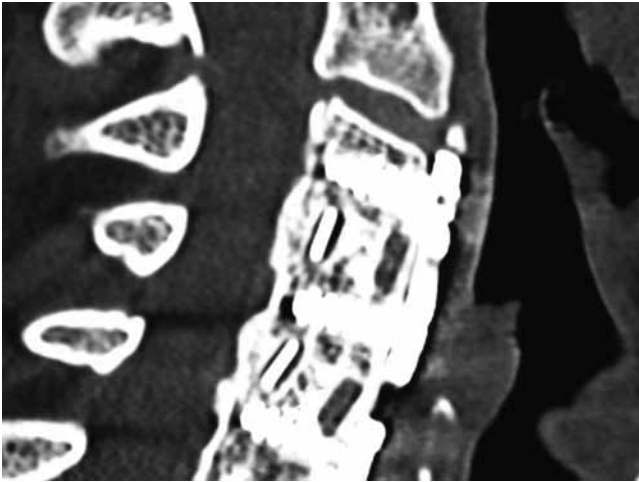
Fusion is evident on the CT scan obtained in this patient at 6 months after surgery.
